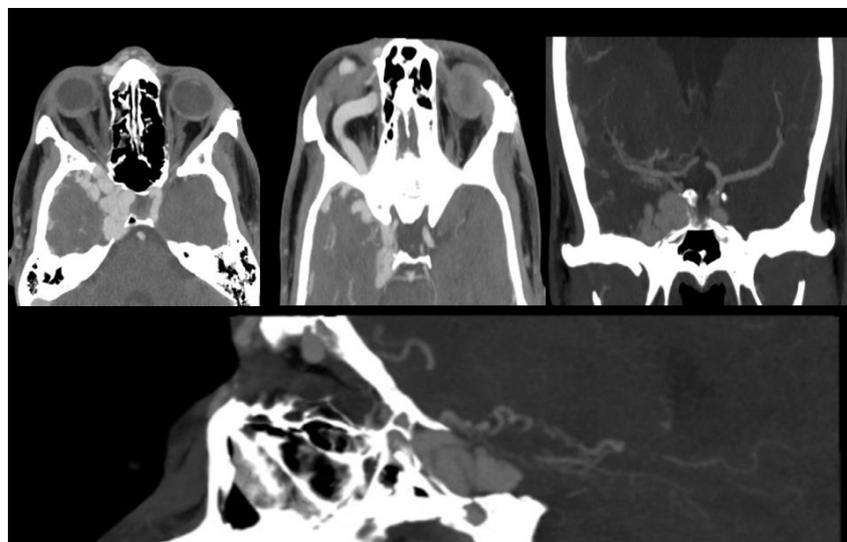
One year later the patient was referred for exophthalmos with headaches. The CT scan showed an enlargement of the cavernous cavity and the homolateral sphenoidal fissure with a dilated aspect of the right carotid siphon in its intracavernous portion and of the superior ophthalmic vein, with the development of a craniofacial collateral arterial circulation associated with a left exophthalmos grade III, an aspect suggestive of a posttraumatic carotidocavernous fistula
